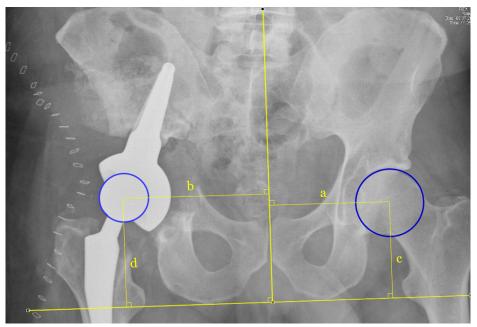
Measurement of the center of rotation (COR) on postoperative anteroposterior radiograph. A best-fit circle was drawn over the femoral or prosthesis head. "a" represents the horizontal distance from the center of the contralateral native femoral head to the vertical midline; "b" represents the horizontal distance from the prosthesis head to the same midline. Distance "c" is the vertical distance from the contralateral head center to the inter-ischial line; "d" is the corresponding distance on the operated side. COR displacement in the mediolateral direction was calculated as a - b and in the superoinferior direction as d - c, corrected for radiographic magnification.
